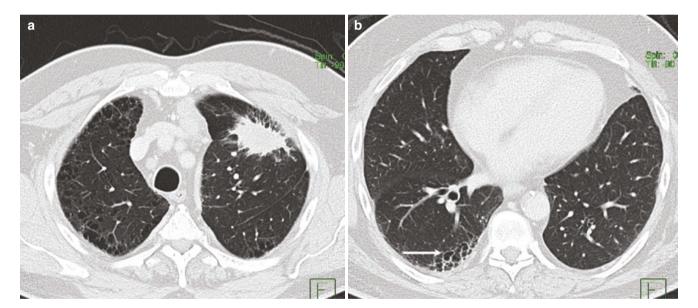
Presumed CPFE with lung cancer. (a) Axial CT image of the upper lungs shows paraseptal emphysema and a spiculated nodule. (b) Axial image of the lower lung shows a cluster of TWLCs (white arrow) in the right lower lobe. There was fibrosis in the lung bases (not shown)
